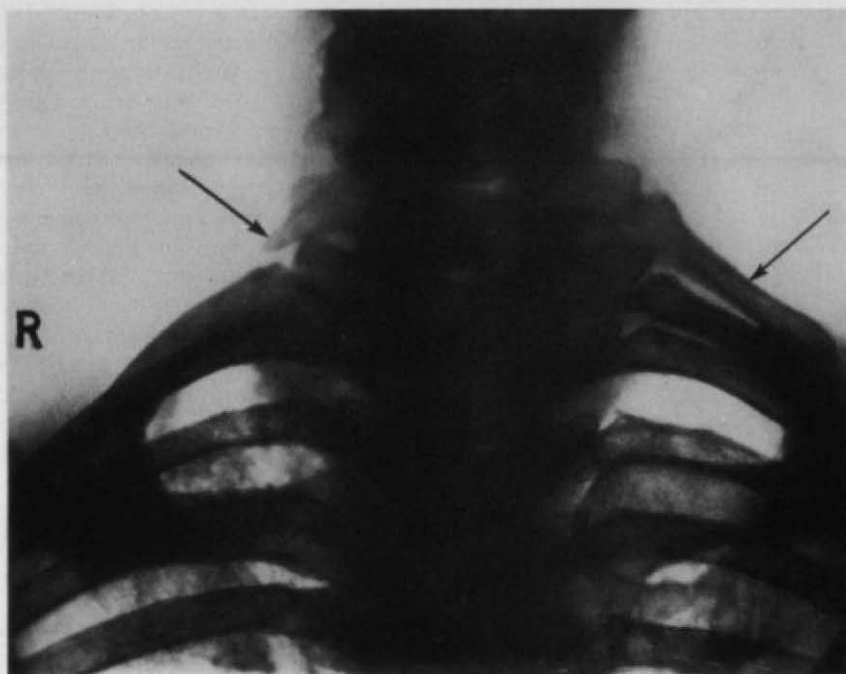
Radiograph of a left cervical rib. On the right the anterior tubercle of C7 vertebra is greatly enlarged; a fibrous band passed from this tubercle to the first rib.
